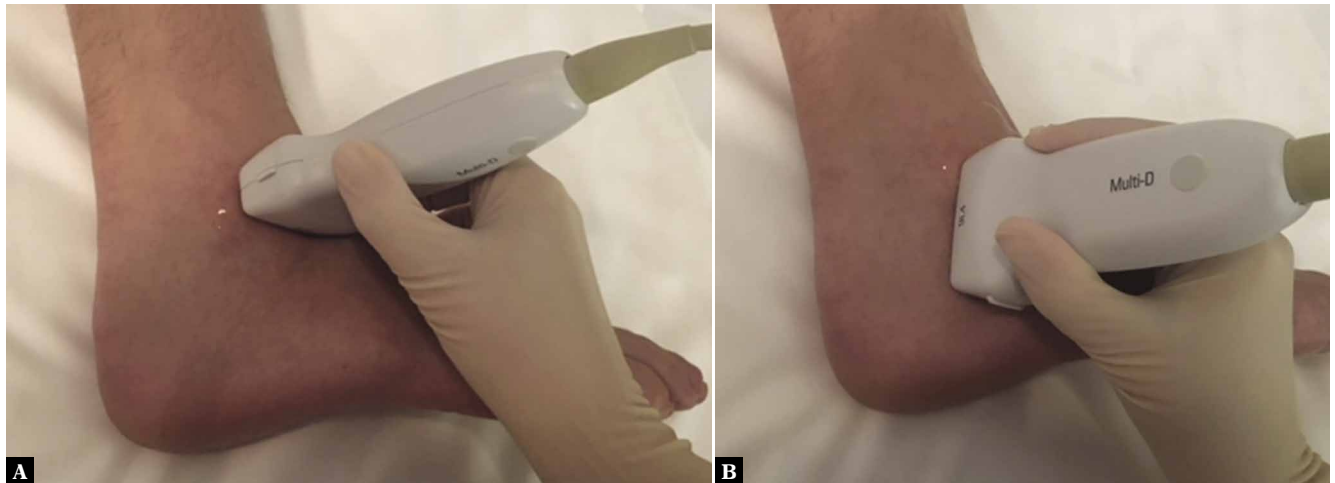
Positioning of the foot and ultrasound transducer for the evaluation of the (A) ATFL and (B) CFL in the long axis
